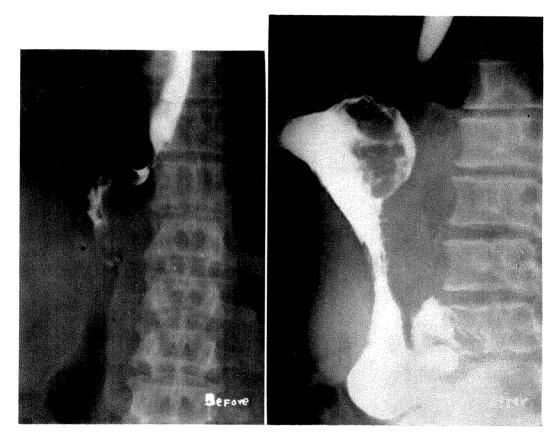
M. McK., female, aged sixty-nine. Difficulty in swallowing both solid and liquid foods for several weeks. Roentgen studies revealed a stenosis of the lower erd of the esophagus. The obstruction was so marked that the patient could take only small amounts of the opaque mixture. Carcinoma of the esophagus was suspected, but satisfactory examination was impossible. After the administration of 1/100 grain of nitroglycerine, the esophageal obstruction disappeared. An extensive neoplasm of the cardia of the stomach without involvement of the lower end of the esophagus was 4 monstrated.
